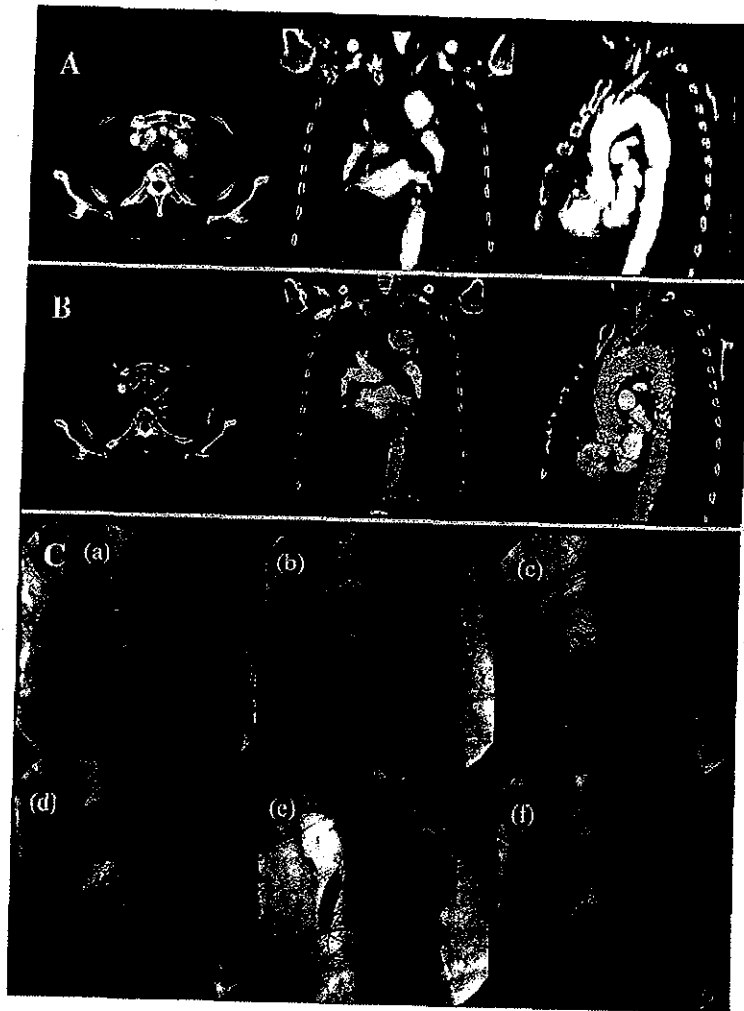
The successful implantation of the Inoue single-branched stent graft is shown for patient 16 in Table 1. A, Enhanced computed tomography (CT) scan before treatment. B, Enhanced CT after treatment. C, Angiogram during the procedure. *a*, The folded Inoue stent-graft was delivered and positioned. *b*, The distal part of the aortic section of the graft, the distal neck was dilated. *c*, After unfolding the proximal part of the aortic section, the proximal part of the aortic section was dilated. *d*, The proximal part of the aortic section was dilated. *e*, The branched section was dilated. *f*, The final angiogram revealed complete exclusion of the aneurysm.
